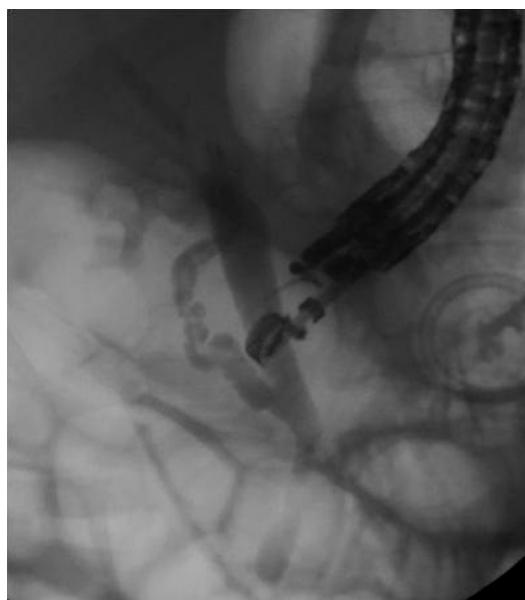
Puncture of the common bile duct by ultrasonography with contrast injection.
